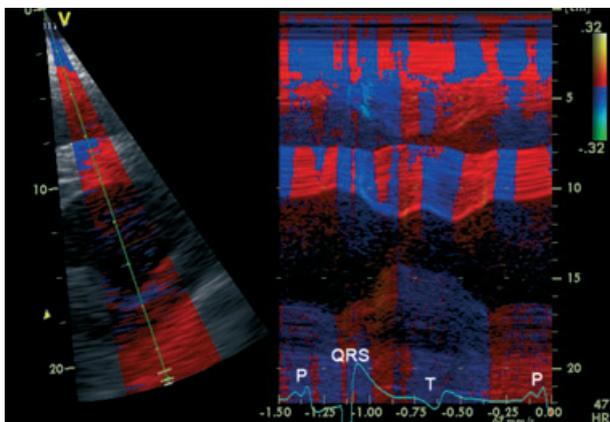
Short-axis 2D (left panel) and M-mode (right panel) image at papillary muscle level with tissue Doppler imaging (TDI). The biphasic wall motion in the interventricular septum is characterized by the alternation of red and blue TDI color codes, indicating wall motion velocities toward and away from the transducer, respectively.
